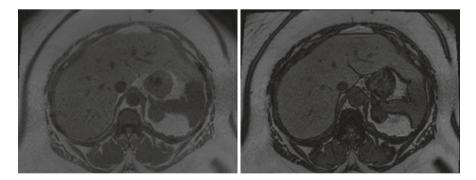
Axial in and out-of-phase MR imaging through the upper abdomen demonstrating a 2.6 cm left adrenal nodule with loss of signal on out-of-phase imaging, compatible with intracellular lipid and an adrenal adenoma
